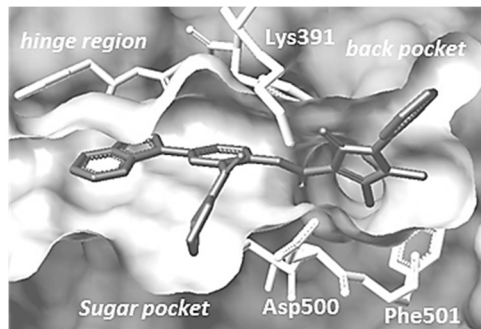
Xray structure of new inhibitor
